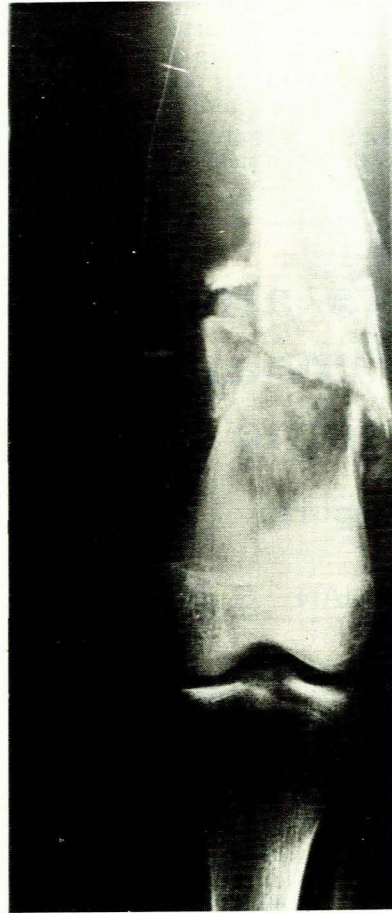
Radiograph of right leg showing pathological fracture through an area of radiolucency caused by an intra-osseous osteolytic malignant tumour. Subperiosteal formation of new bone is observed proximal to the fracture.
